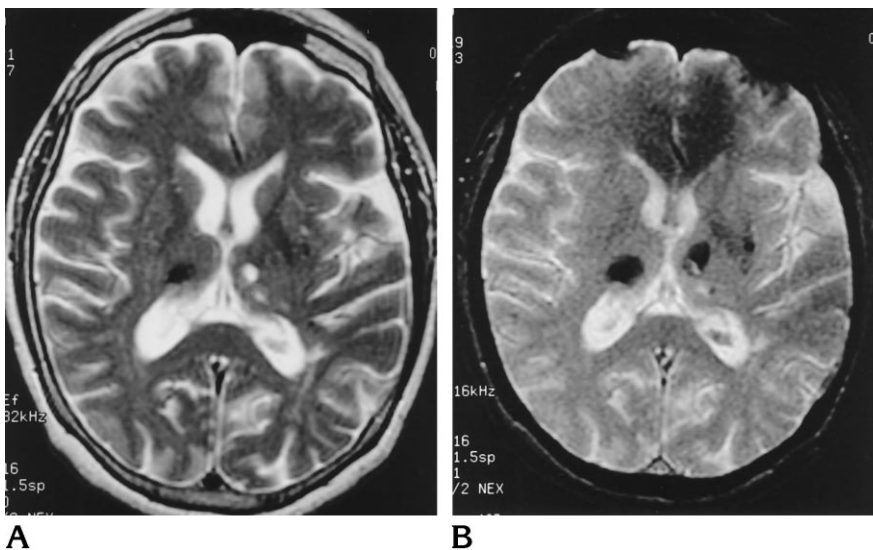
A, T2-weighted fast spin-echo MR image shows a hyperintense lesion within the left thalamus and a hypointense lesion within the right thalamus. A smaller hyperintense lesion is seen within the left thalamus. A small hypointense lesion is identified within the left putamen, but this is less visible than the thalamic lesions.
